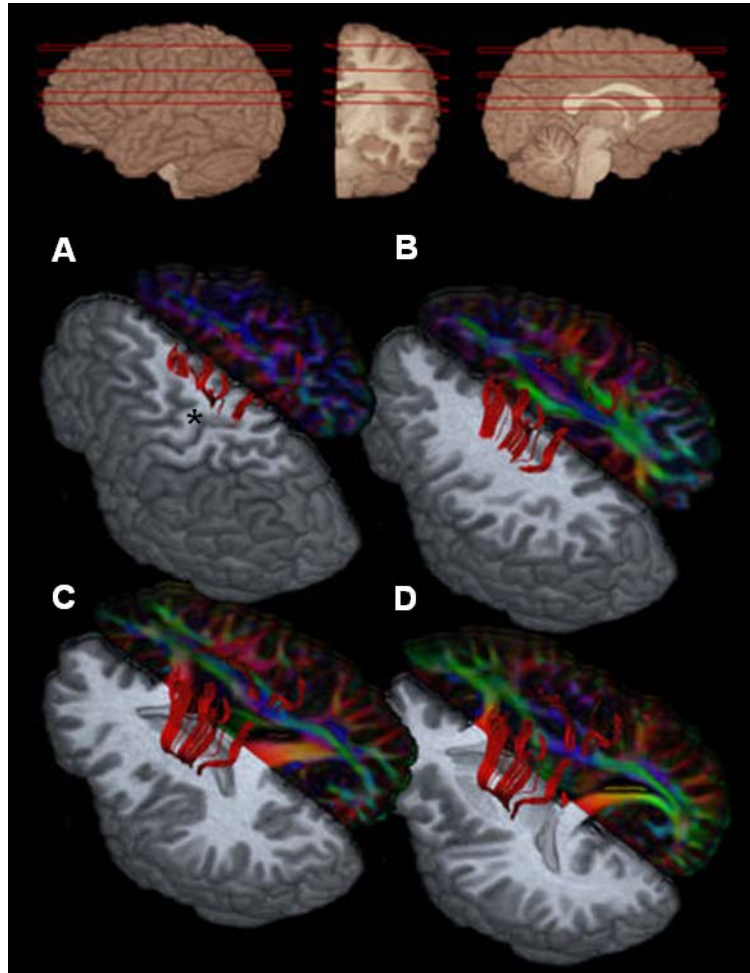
Specific regions evaluated to determine the integrity of the CST. Transaxial summed volumetric high-resolution T1-weighted images, FA color-maps, and tractograms show the origin of the CST from both the MC (asterisk at precentral gyrus) and PMC (A). The CST involves the CS (B) and CR (C) and finally converges at the level of the PLIC (D). The sectional levels are indicated as red horizontal lines (upper images).
